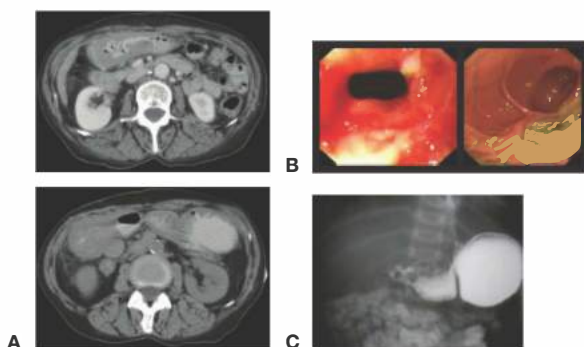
• Radiology. A. CT scan of pyloric obstruction from chronic pyloric inflammation. B. Endoscopic image of near-complete pyloric obstruction from chronic pyloric inflammation (left); endoscopic image of a large gastric ulcer with a central necrotic region (right). C. Contrast radiography demonstrating pyloric obstruction from chronic pyloric inflammation.
